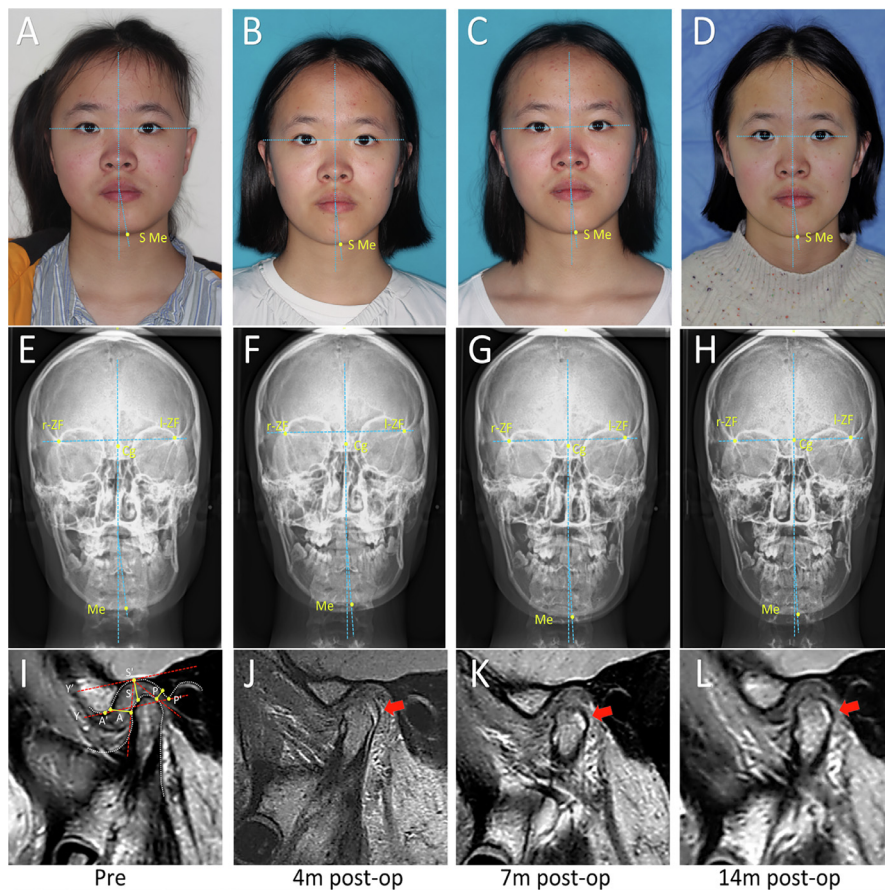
A 17-year-old girl before and after combined left side disk repositioning and orthodontic functional appliance. (A), (E) Preoperative facial profile and posteroanterior cephalometric radiographs showed chin deviated to the left. (B), (F) Images taken 4 months after disk repositioning showed chin deviation was corrected. (C), (G) Seven months after operation; (D), (H) 14 months after operation. (I)-(L) Joint space measurement after disk repositioning showed that superior and posterior space on the condyle was increased and new bone formation (red arrows) from 4 to 14 months after operation. S Me, soft tissue menton point; Me, menton point.
